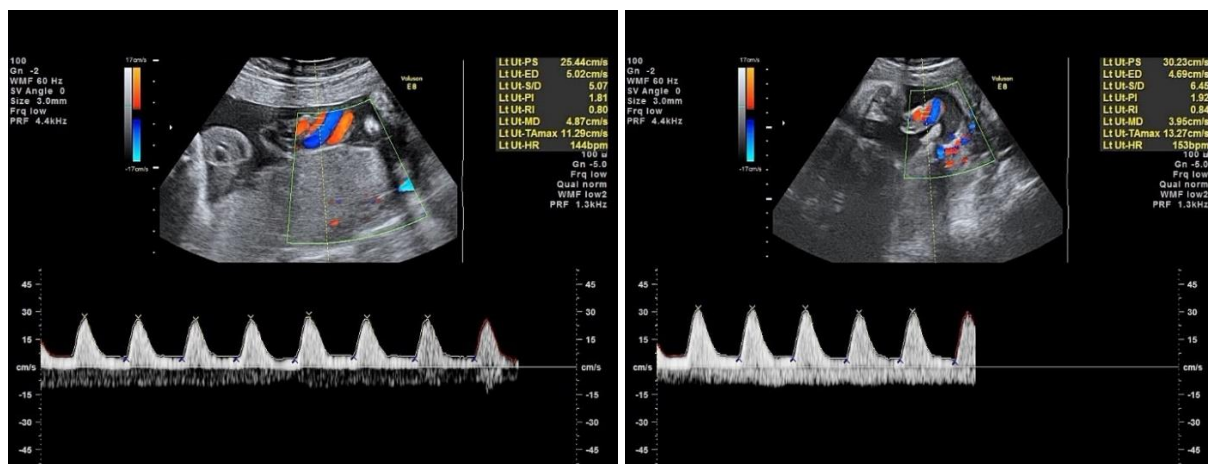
Doppler velocimetry with decreased telerdiastolic flow in the umbilical artery due to pathologically increased resistance in the placental territory; cerebroplacental ratio of 1.26, corresponding to the 3rd percentile: severe symmetric FGR
